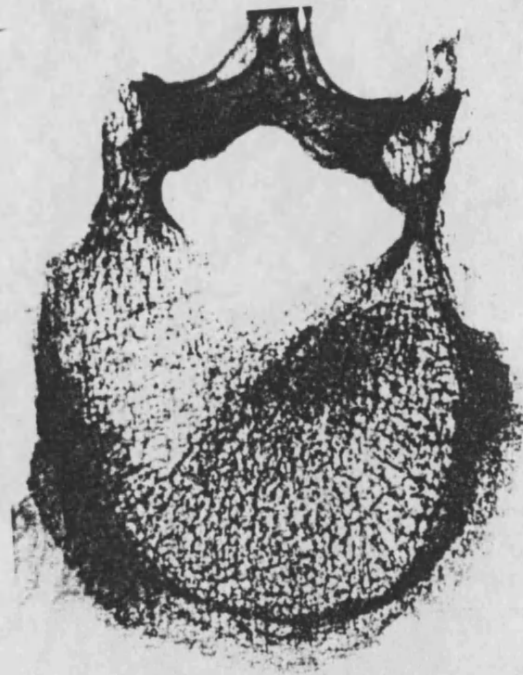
X-ray of sample 2.
